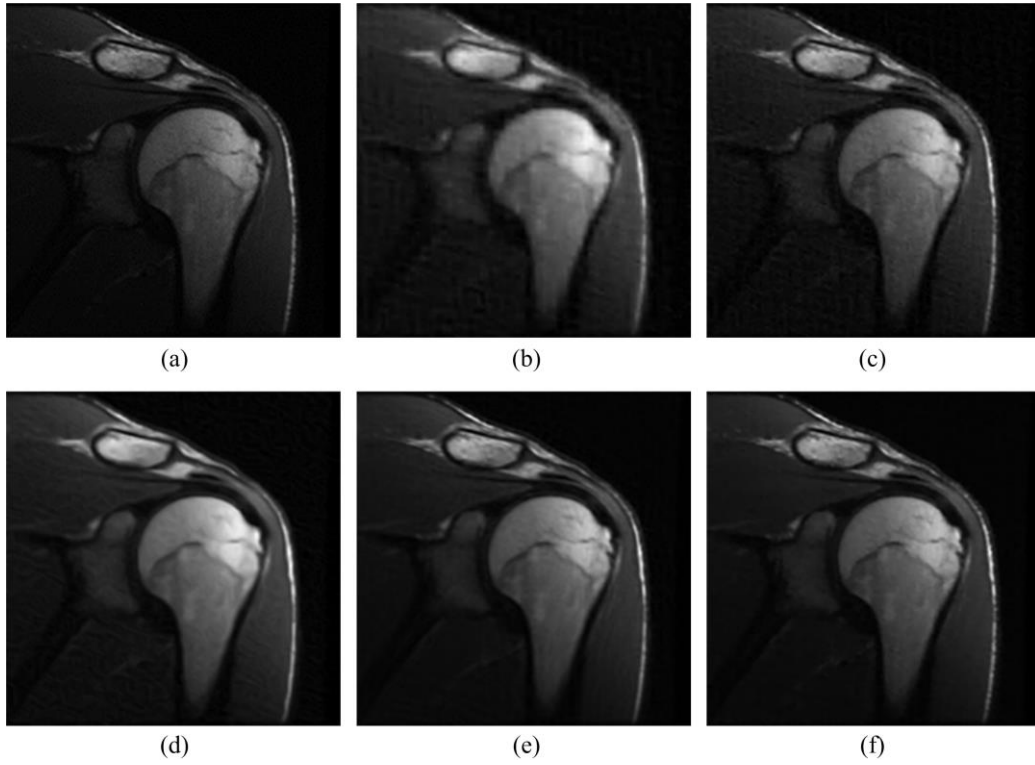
Results of reconstruction on the shoulder MR image using different methods with 15% sampling. (a) Original MR images; images reconstructed using, (b) SparseMRI, (c) FCSA, (d) Framelet+NLTv, (e) Shearlet+TGV, (f) Data-driven TF+TGV (proposed).
